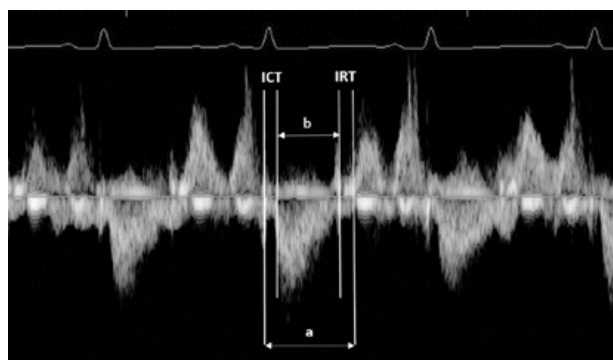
Pulsed Doppler tracing obtained from the apical five-chamber view with echocardiography tracing for timing above. Measurement of myocardial performance index (MPI; Tei index) of left ventricle. $MPI \text{ (Tei index)} = ICT + IRT/ET = a-b/b$; ICT — isovolaemic contraction time; IRT — isovolaemic relaxation time; ET — ejection time
